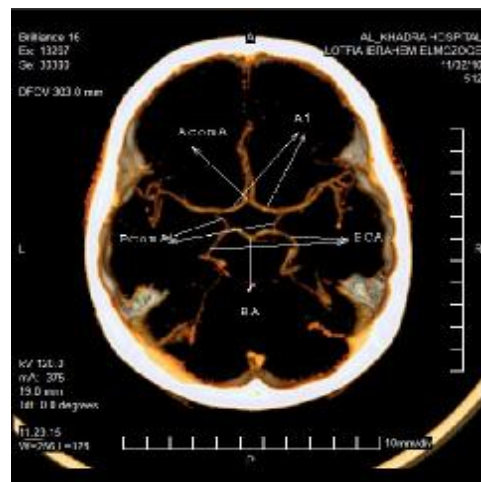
CTA showing a classical circle of Willis.
